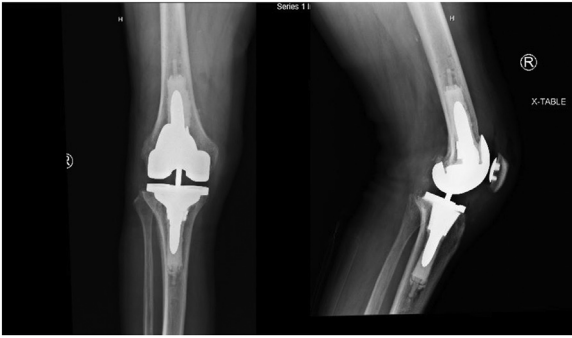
AP and lateral postoperative radiographs of right total knee arthroplasty revision utilizing robotic arm assistance. Implants used: Femur – Cemented Stryker Triathlon TS #5 with 15 mm × 50 mm stem, 10-mm medial and lateral posterior augments, and size 1-2 Tritanium cone; Tibia – Cemented Stryker Triathlon universal tibial baseplate size 4 with 12 mm × 50 mm stem, and size A Tritanium cone; Polyethylene – Stryker Triathlon X3, size 4 TS x 13mm; An Artisan Bone Plug Med was used in the tibia and femur [7].
